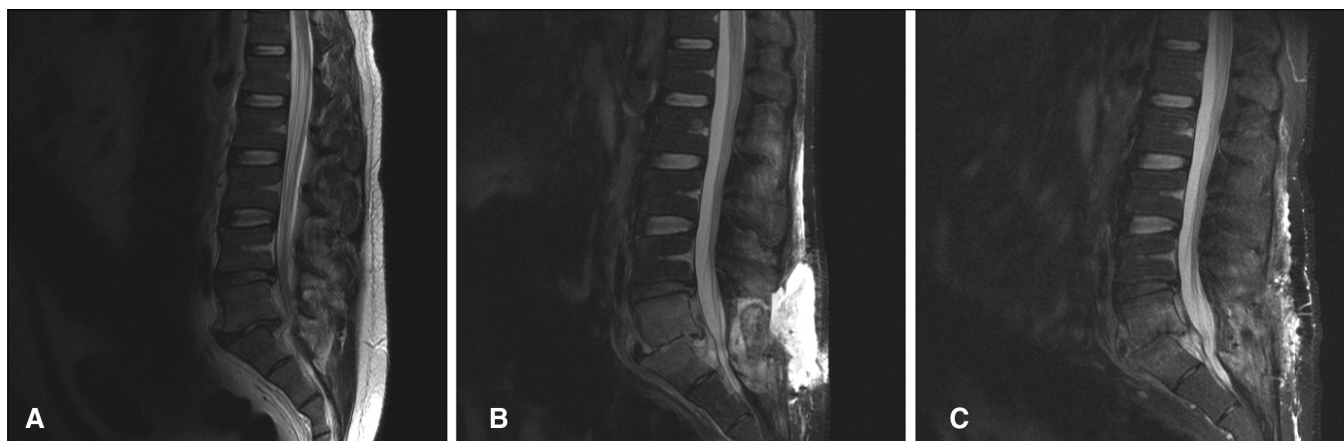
Serial T2-weighted magnetic resonance imaging scans of the lumbar spine before and during treatment showing progression and resolution of fluid collection (A – day 0, preoperative; B – day 35; C – day 78)
